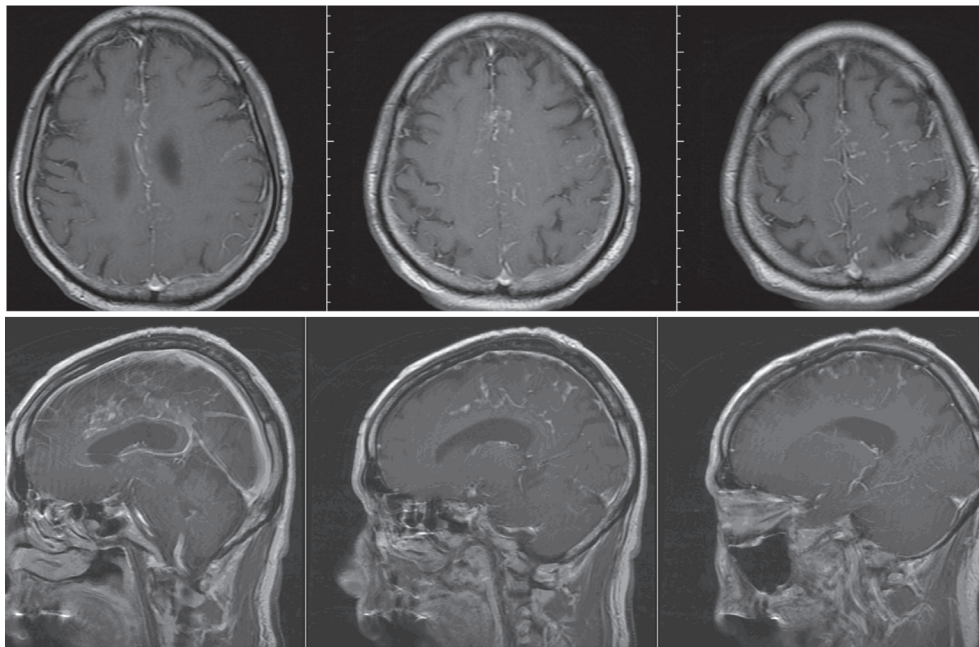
Brain MRI with Gd-DTPA enhancement showed multiple contrast-enhanced leptomeningeal lesions.
